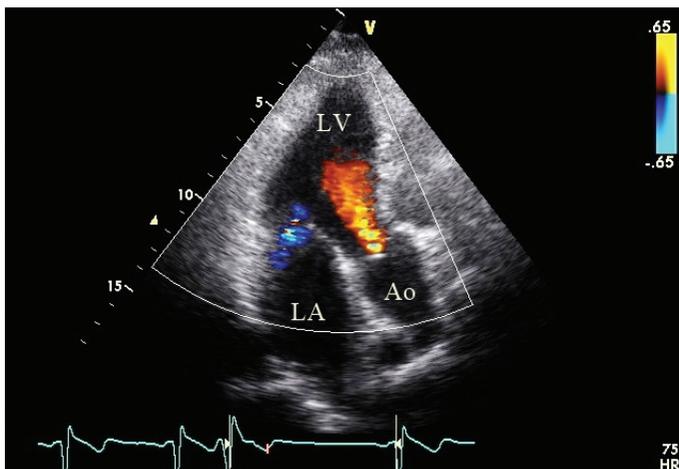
Color Doppler echocardiography showing simultaneous aortic and mitral regurgitation flows during the systolic phase of the premature ventricular beat
